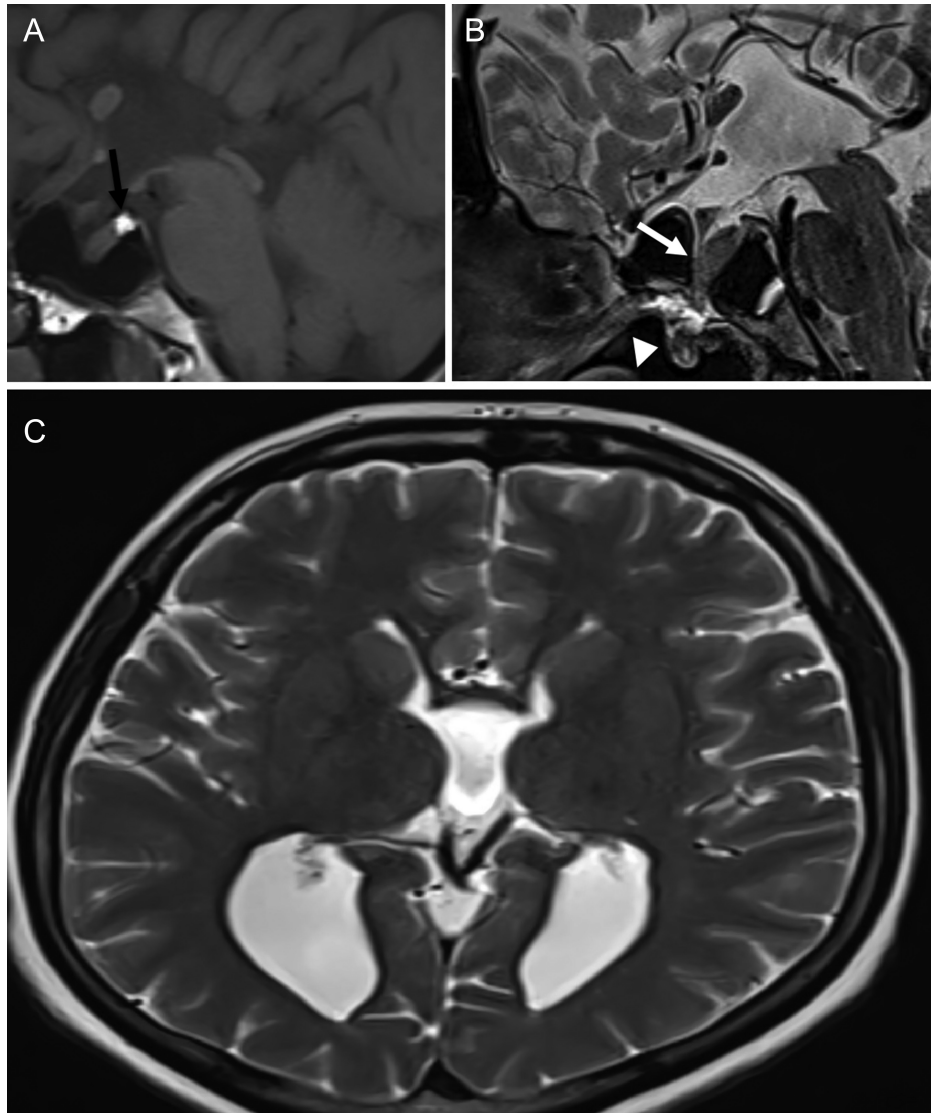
(A) Sagittal T1W, normally located neurohypophysis (black arrow). (B) The anterior pituitary gland extends from the persistent craniopharyngeal canal (white arrow) to the nasopharyngeal cavity (white arrowhead) and corpus callosum agenesis. In the sagittal T2W 3D-SPACE sequence (C) axial T2W, parallel configuration of the lateral ventricles and dilatation of the occipital horns secondary to corpus callosum agenesis. T1W, T1-weighted; T2W, T2-weighted.
